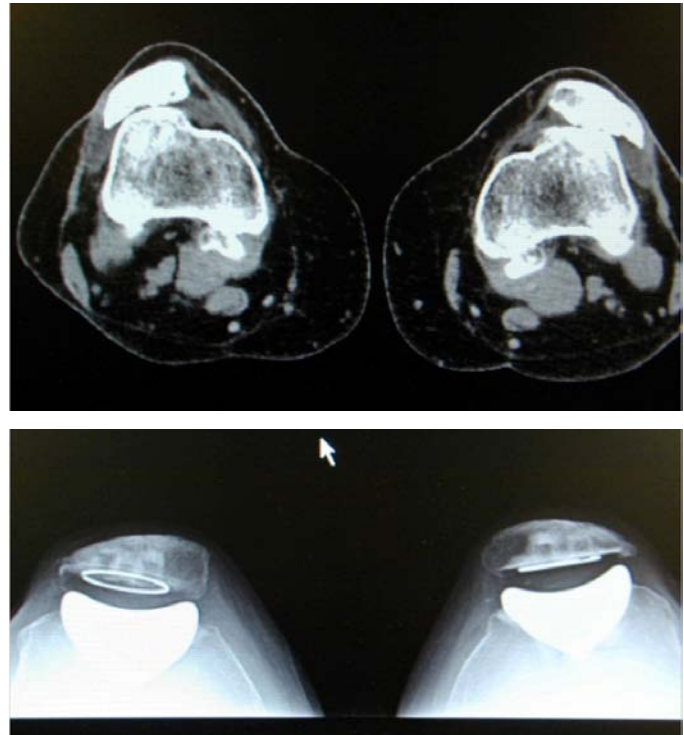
Radiographic imaging of severely dysplastic trochlea (A) pre-operative and (B) post-operative.
